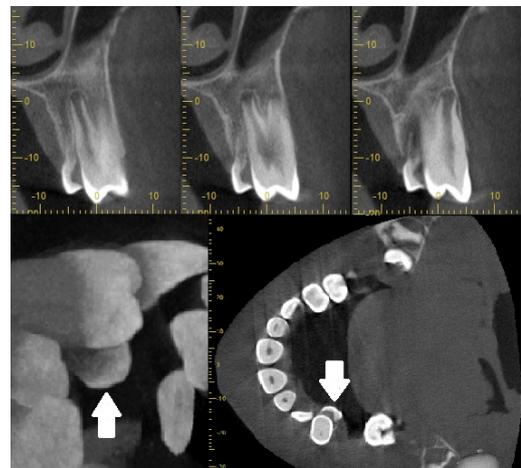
The multiplanar CBCT images of the related area. (White arrows show the abnormal structure).
